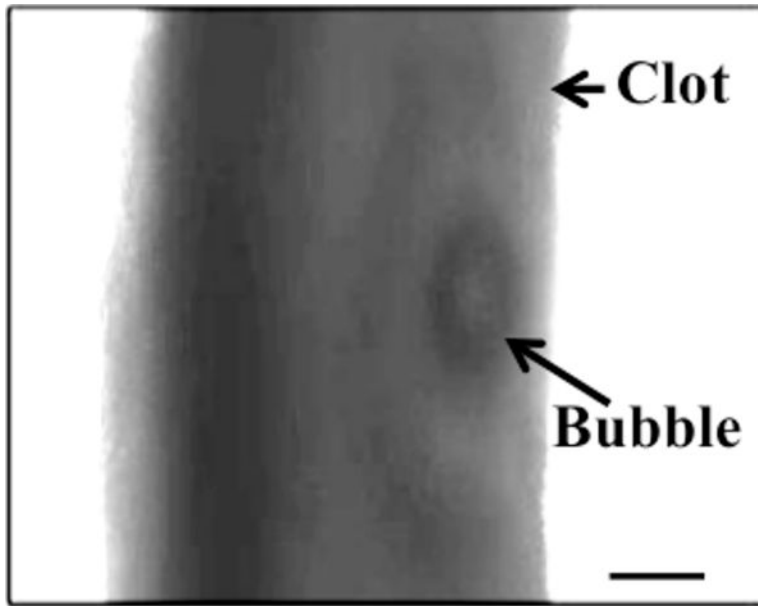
Coalescence and translation of bubble. *(a)* Prior to insonation, three bubbles are visible on the clot. *(b)* The three bubble coalesce within 400 ms after ultrasound exposure. *(c)* The resultant bubble translates after remaining stationary for 3.5 s. The surrounding fluid contains recombinant tissue-type plasminogen activator (0.32 $\mu\text{g}/\text{mL}$), and Definity[®] (2 $\mu\text{L}/\text{mL}$). The bubble appears distorted due to the long exposure time of the camera (16 ms) compared to the acoustic period (8.33 μs). The scale bar in panel *a* is 100 μm .
